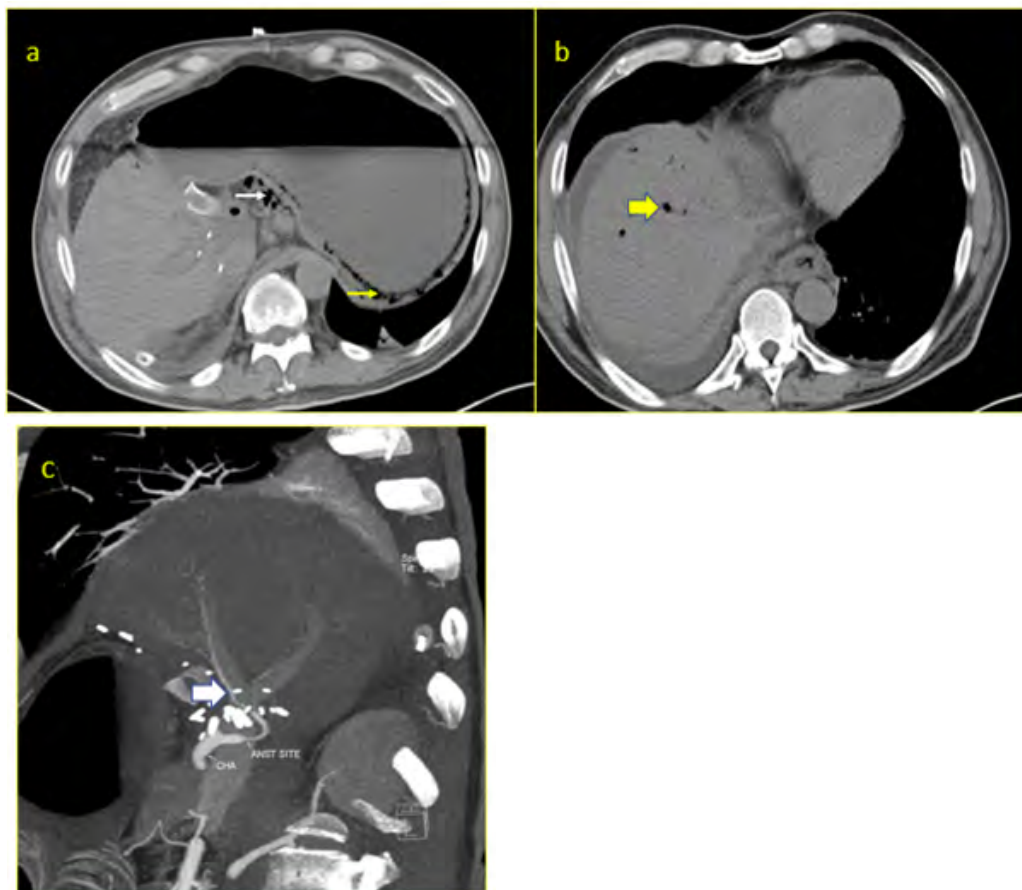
Post LDLT , 62/M (LAR-2) . Portal vein gas was detected on routine post operative doppler on POD-3 and POD-4. Plain CT of the upper abdomen on POD-4 (a, b) demonstrates intramural air in the stomach (yellow arrow) , in the peri gastric vessels (white arrow) and in the liver parenchyma (yellow block arrow). CT angiography was performed as the hepatic artery could not be evaluated due to the gas causing excessive spikes in the doppler spectrum. Oblique MIP image (c) shows maintained patency of the hepatic artery (white block arrow) and its divisions within the allograft. The patient was stable and subsequent doppler studies showed resolution of the portal vein air on POD -6 and resolution of the intramural gastric air on a follow up plain CT on POD- 7. A diagnosis of Gastric emphysema was made and the patient was later discharged in a stable condition.
